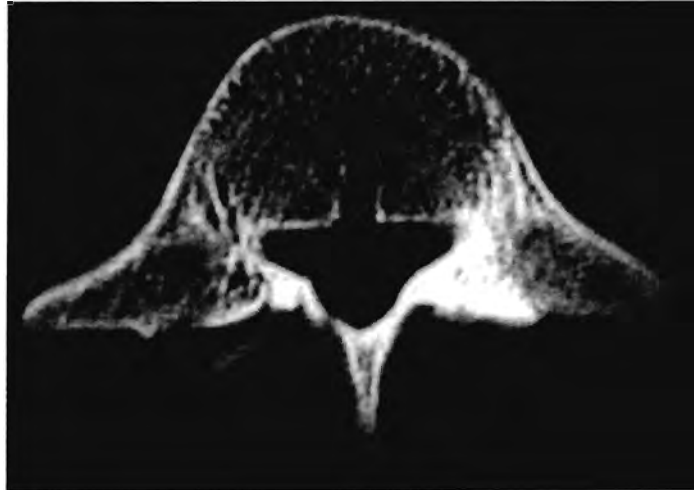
A CT scan of an 18-year-old right arm bowler (subject 4) showing a healed left pars interarticularis fracture and a partially healed right interarticularis fracture of the 4th lumbar vertebra.
